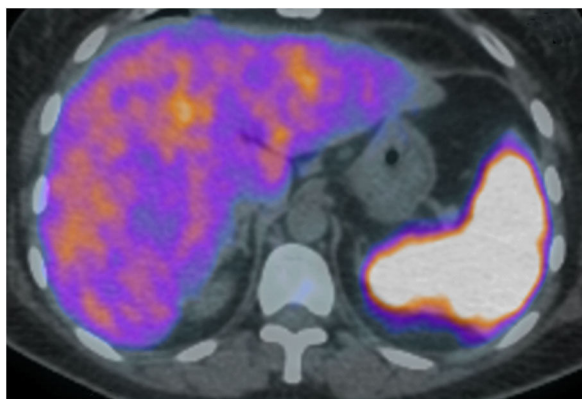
Axial PET/CT scan that confirms the increased SUV at liver and splenic level.
